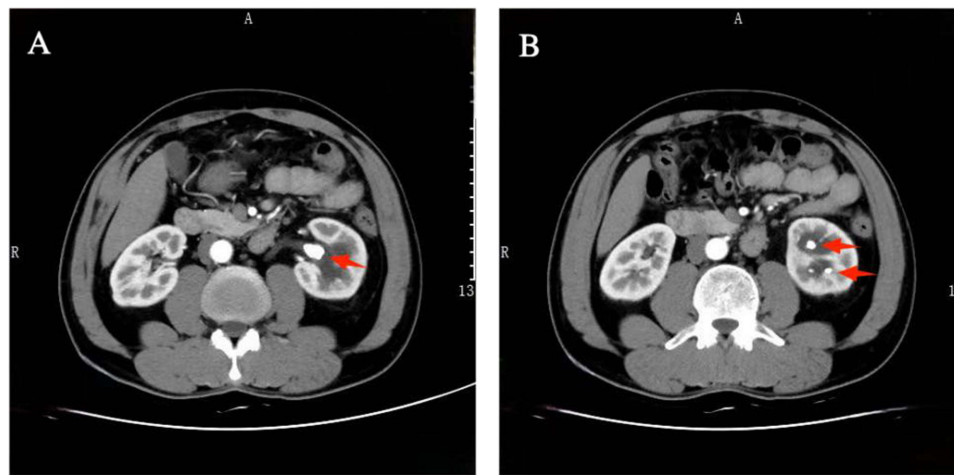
Preoperative CT images. (A) Showing calculi (red arrow) in the left pelvis. (B) Showing multiple calculi (red arrows) in lower calyx at a transverse plane.
